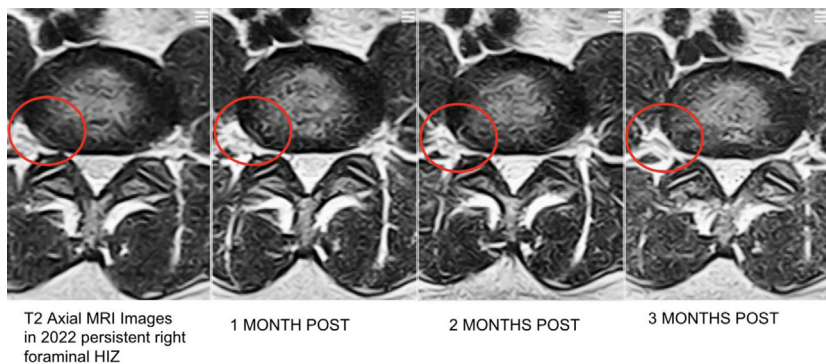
Serial T2 axial MRI images over time demonstrating structural changes of the right-sided annular fissure and protrusion post-intradiscal LR-PRP precisely delivered with a curved catheter.
